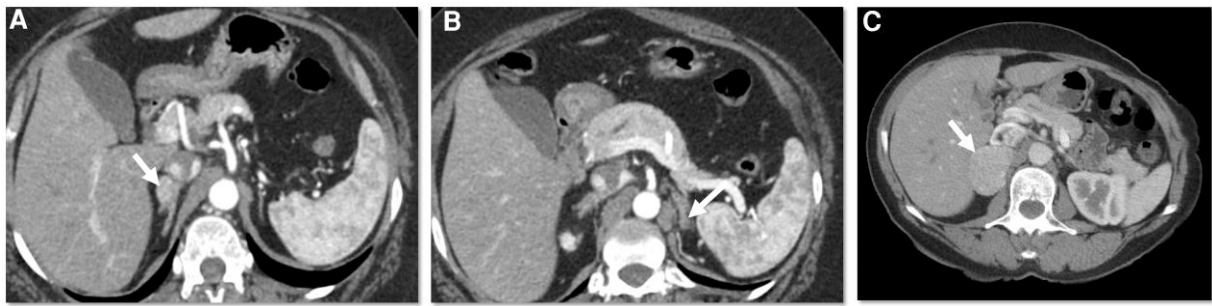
(A, B) Case 1. (A) Abdominal CT revealing an undetermined right adrenal nodule measuring 1.8 × 1.2 cm (white arrow) with 18 Hounsfield unit (HU) in the precontrast phase with arterial phase peak enhancement of 117 HU and an absolute washout of 65%. (B) Slight nodular thickening up to 1.4 × 0.8 cm (–4 HU) in the left adrenal gland (white arrow), suggestive of adenoma. (C) Case 3. Abdominal CT revealing a right adrenal nodule measuring 5.2 × 4.0 cm (white arrow) with 34 HU in the precontrast phase with arterial phase peak enhancement of 122 HU and an absolute washout of 75%.
